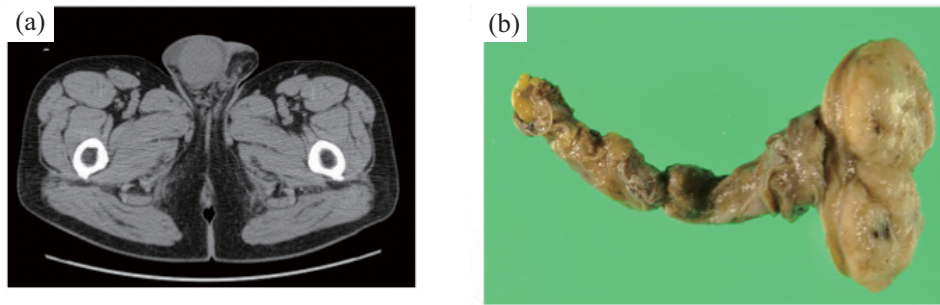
Testicular findings. (*Ia*) Pelvis plain computed tomography showed right testicular enlargement. (*Ib*) Macroscopically, the testicular tumor was a creamy, soft, homogeneous mass.
